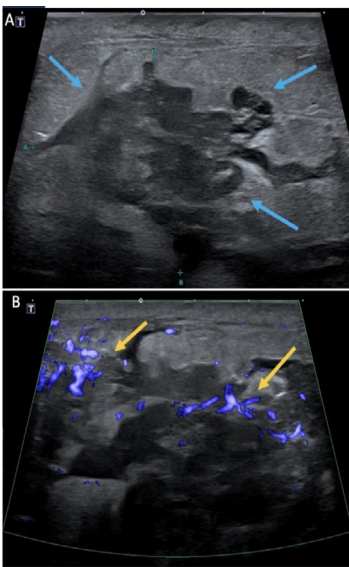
Sonographic grayscale (a) and power doppler (b) images demonstrate diffuse abnormal non-mass tissue with an associated irregular mass with indistinct margins (blue arrows) demonstrating increased blood flow (yellow arrows), corresponding to the mammographic asymmetry. This tissue was targeted for percutaneous ultrasound-guided biopsy.
